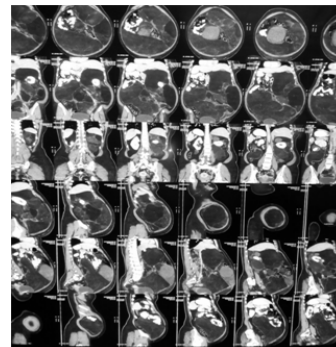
CT scan showing the size and extent of the tumour
